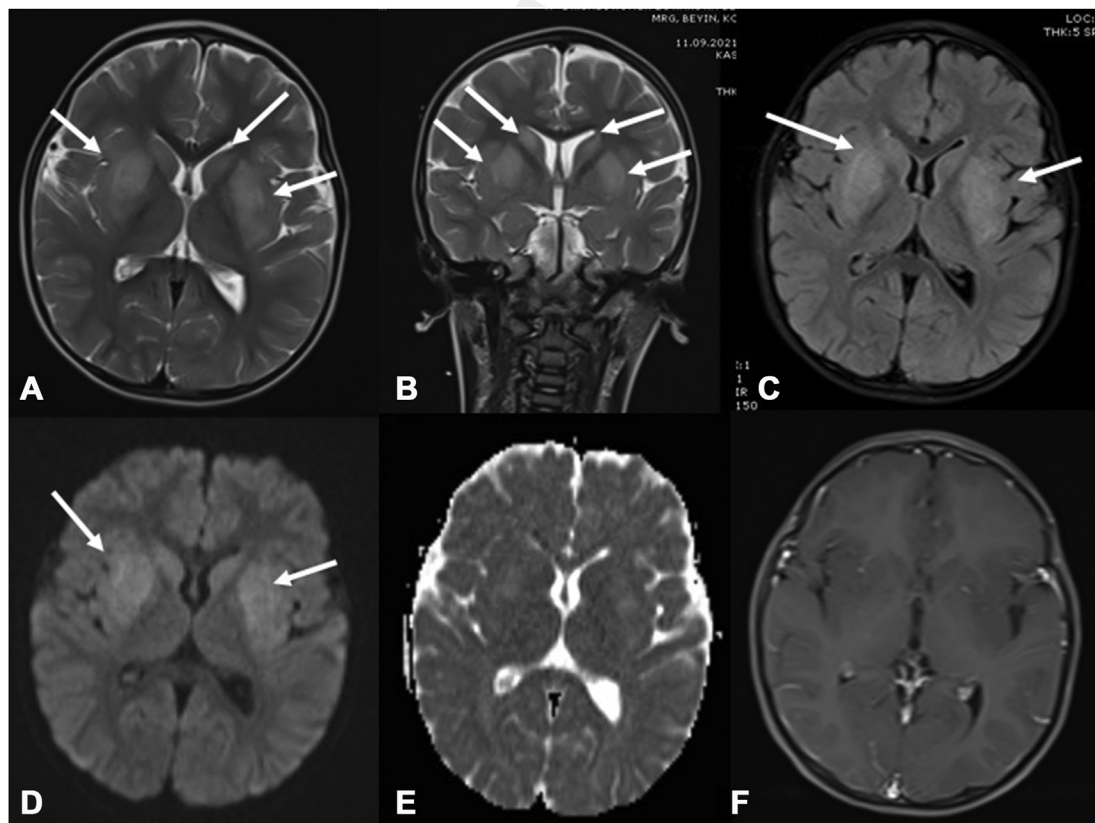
In the cranial MRI examination of the case; Symmetrical pathological signal increases and edema were observed in bilateral lentiform and caudate nuclei in T2W axial (A), coronal (B) sections, and FLAIR(C) sequences. Diffusion-weighted sequence (D) and ADC mapping (E) show increased diffusion in these localizations, and no contrast enhancement was detected after contrast administration (F).
